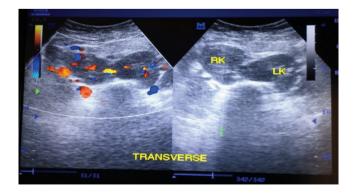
Transabdominal transverse sonograms show right renal hilum faced medially while the left renal hilum faced posteriorly. and colour Doppler highlighting the renal vessels.
